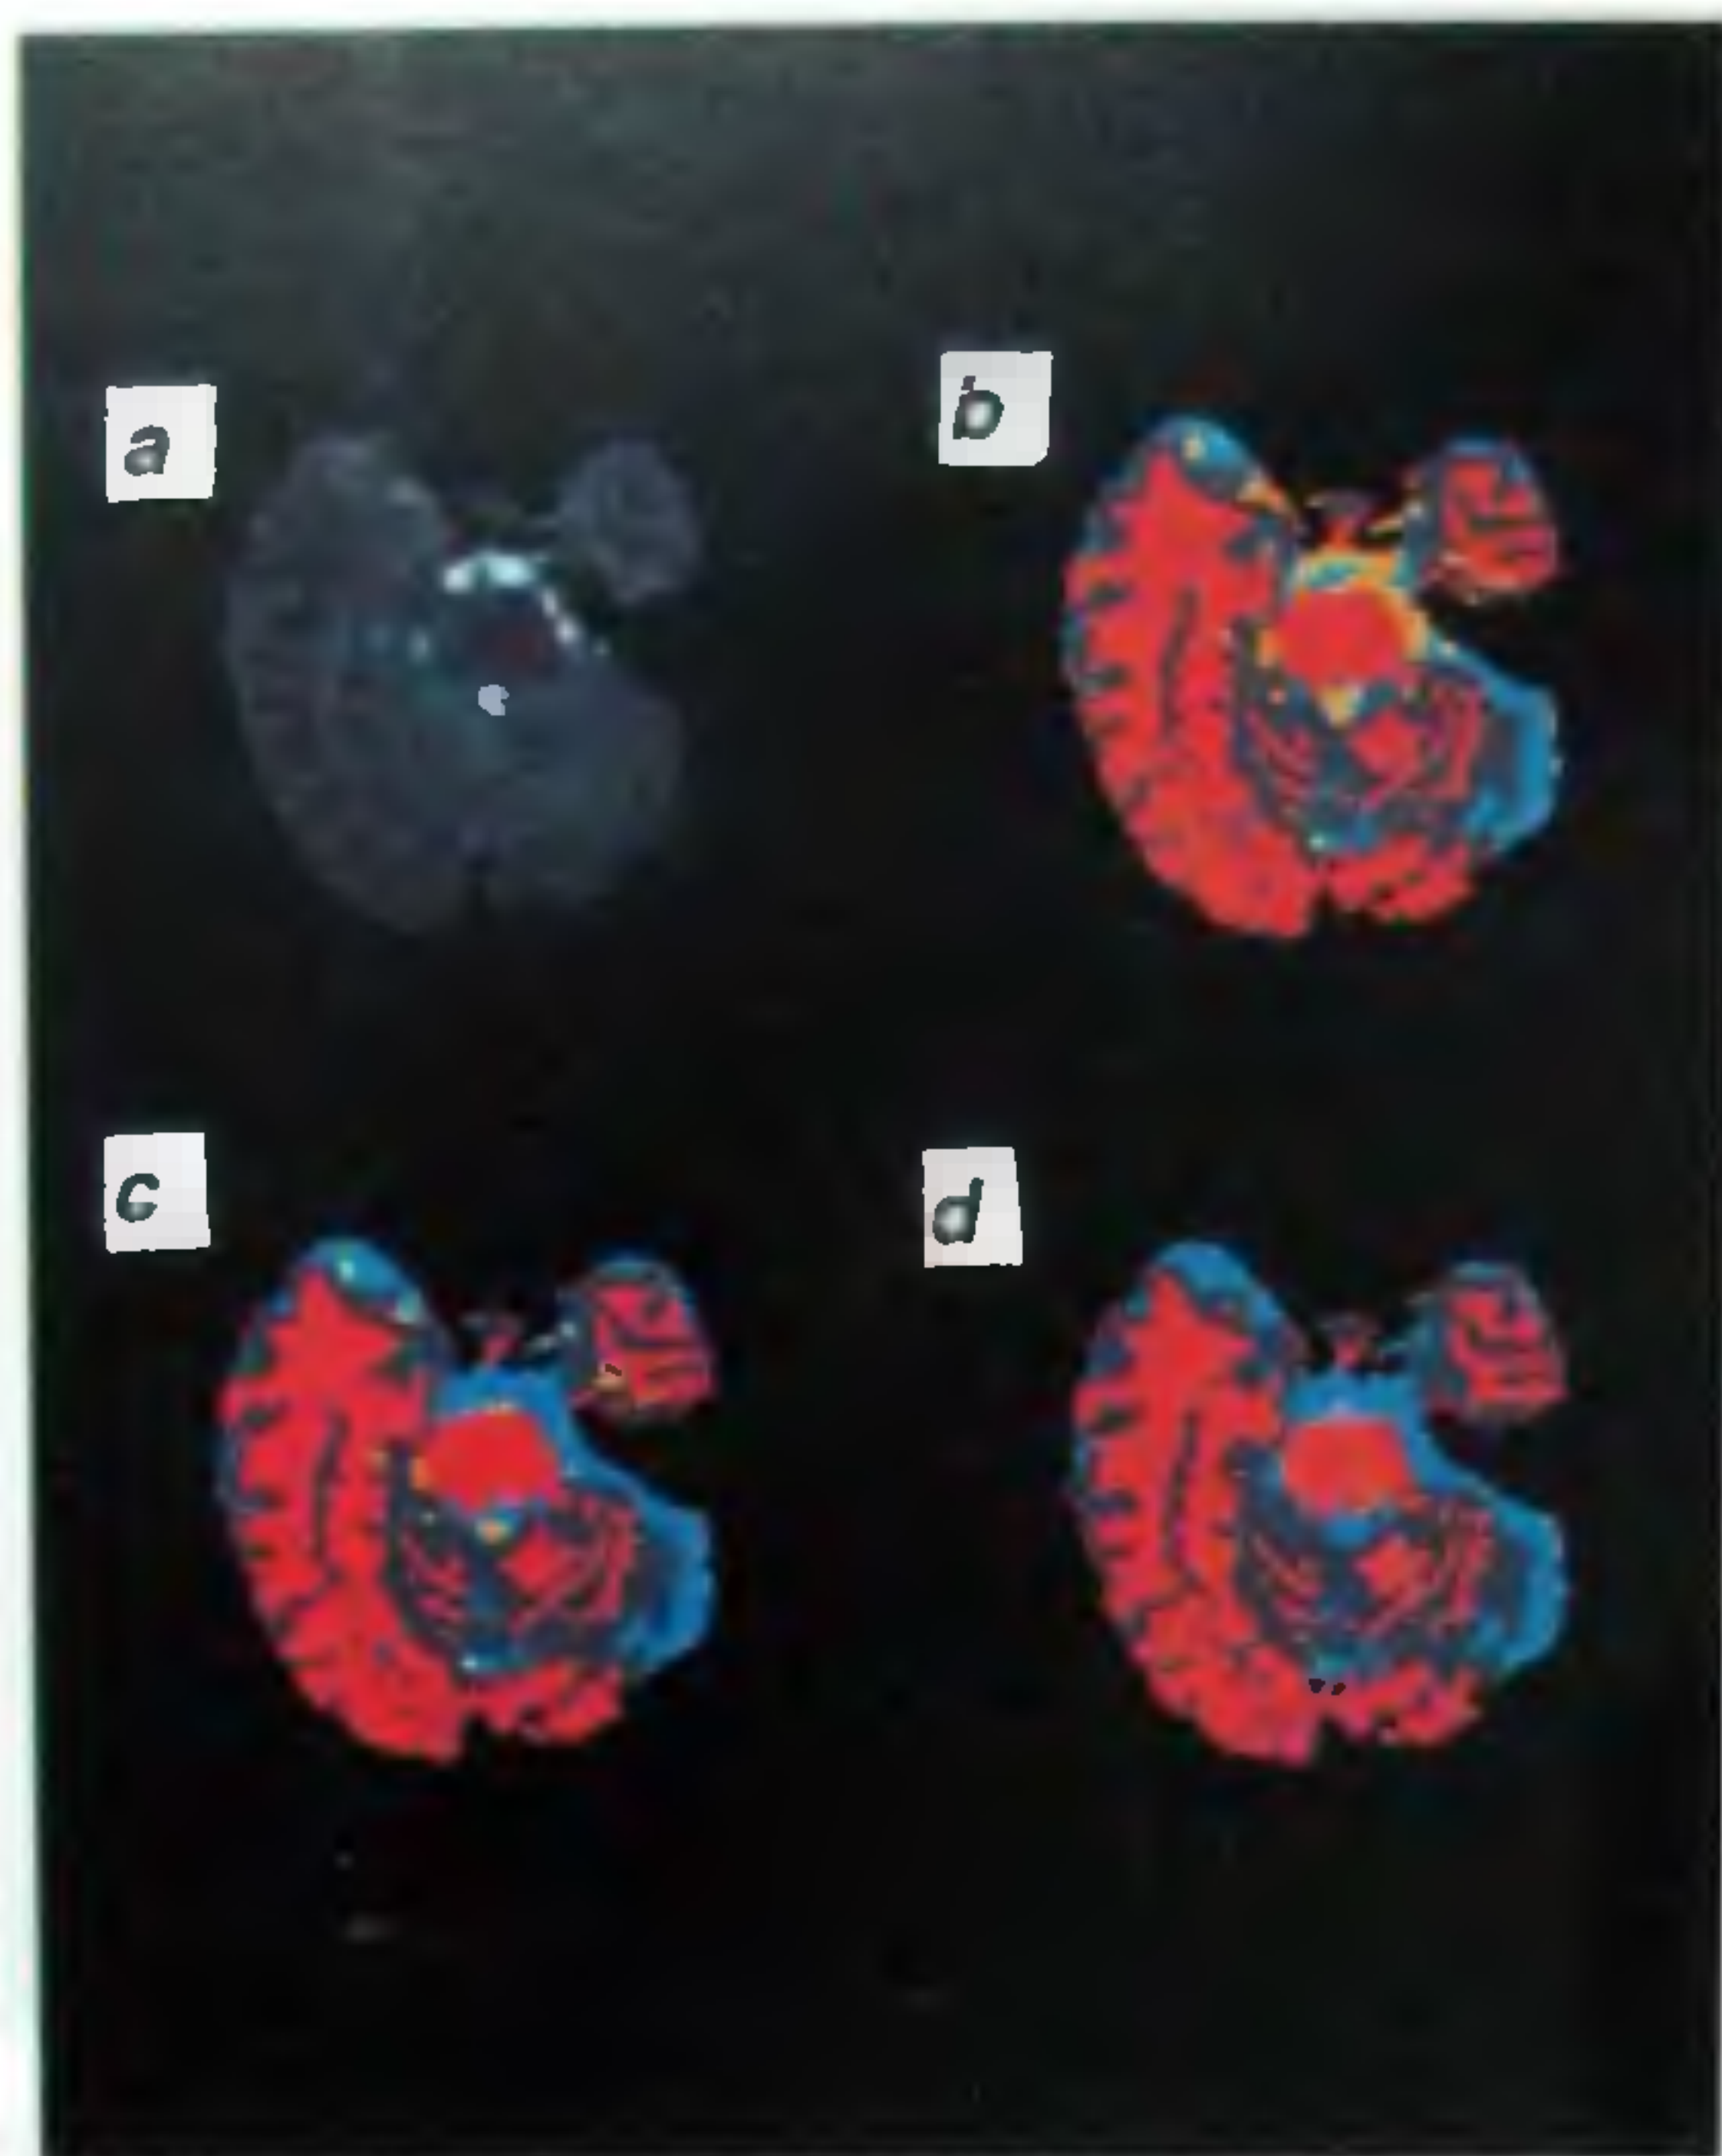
Segmented images based on dual echo FSE, (*c*), and dual echo FLAIR/MTC image, (*d*). WM is represented in pink, GM in grey, CSF in blue, and lesions in yellow. For comparison the early echo FSE, (*a*), and late echo FLAIR/MTC, (*b*), images are also shown. The large number of false positives seen in *b* are mostly eliminated in *c*.
